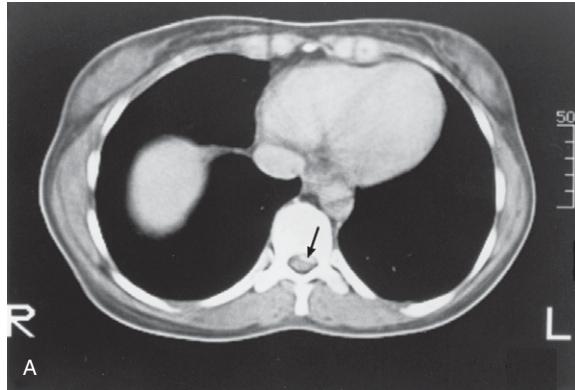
(A) A CT image at the T9–10 level after intravenous contrast. Note the central to left sided calcified extruded disc material in the spinal canal (black arrow). R and L = right and left sides, respectively, of the patient. (B) A lateral thoracic spine plain X-ray image taken 5 months after the CT scan shows a small area of calcification posterior to the T9–10 disc space within the intervertebral foramen (white arrow). 9 = ninth thoracic vertebra; 10 = tenth thoracic vertebra.
